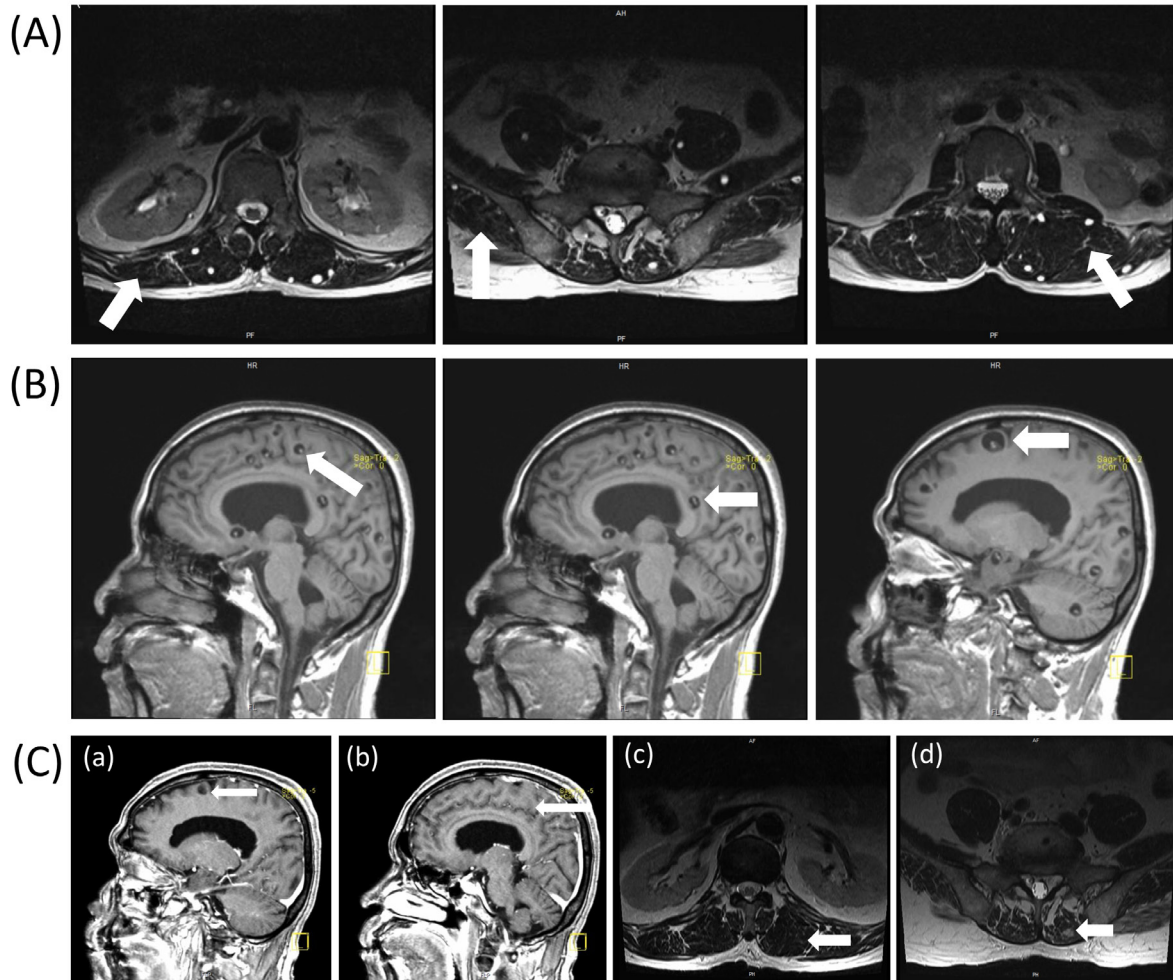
(A) Lumbar MRI shows innumerable intramuscular cysts most suggestive of cysticercosis (red arrows); (B) Brain MRI numerous to count small cystic lesions throughout the bilateral cerebral and cerebellar hemispheres, midbrain, and right ventricle; (C) Brain MRI shows interval decrease in size of the innumerable small cystic lesions throughout the bilateral cerebral and cerebellar hemispheres (a, b); No edema surrounding enhancing lesions. Lumbar MRI shows significant interval decrease in size and number of the innumerable intramuscular cysts (c, d).
